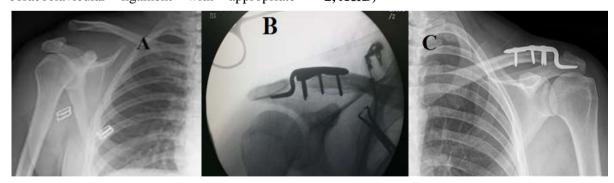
A: preoperative x-ray, B: intraoperative c-arm x-ray, C: post-operative x-ray
